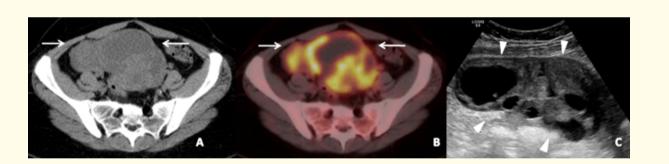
Solid parts in the large adnexal cystic mass (arrows) mass show heterogeneous FDG uptake (a, b). Right adnexal large mixed solid and cystic mass is seen on transabdominal pelvis ultrasound (arrow heads) (c).
